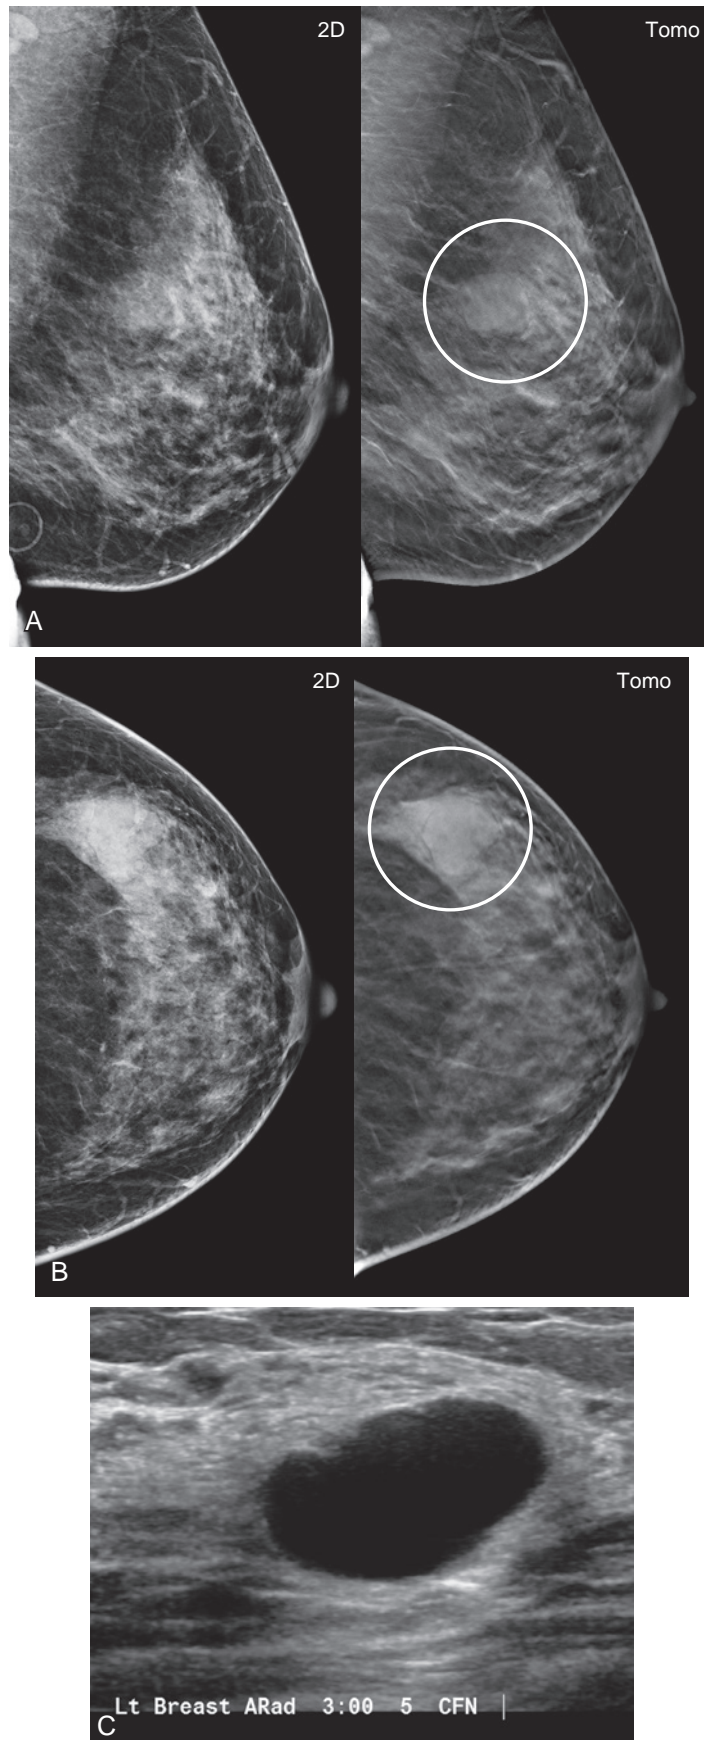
Cyst presenting as dominant mass. Baseline screening mammogram performed in a woman at age 40 demonstrates heterogeneously dense breast tissue. Mediolateral oblique (A) and craniocaudal (B) views in 2D imaging and tomosynthesis reveal a large mass (*circles*) in the left breast at the 3-o'clock position, best seen on tomosynthesis images. The patient was recalled for ultrasound, and no additional mammographic views were required. (C) Ultrasound demonstrates a simple cyst corresponding to the mass in question on screening mammography. BI-RADS 2.
